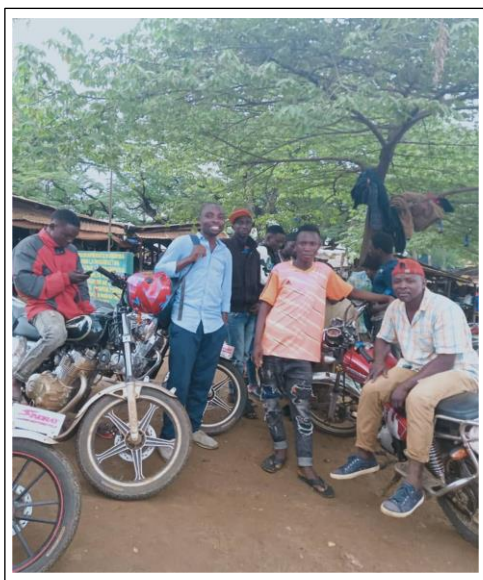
FDG youth champions Boda Boda
